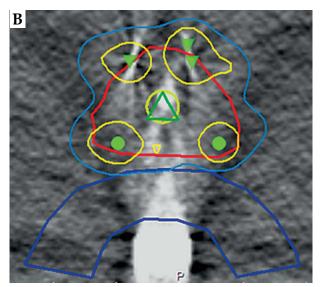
Representative case of cold spot compensation. A significant cold area in the posterior apex of the prostate is evident in a trans-rectal ultrasonography-computed tomography (TRUS-CT) fusion image (A). Two additional seeds were planned to cover this cold spot in the TRUS-CT image. Red line – prostate, dark blue line – anterior rectal wall, yellow circle with green triangle – Foley catheter, light blue line – 145 Gy, yellow line – 217.5 Gy
